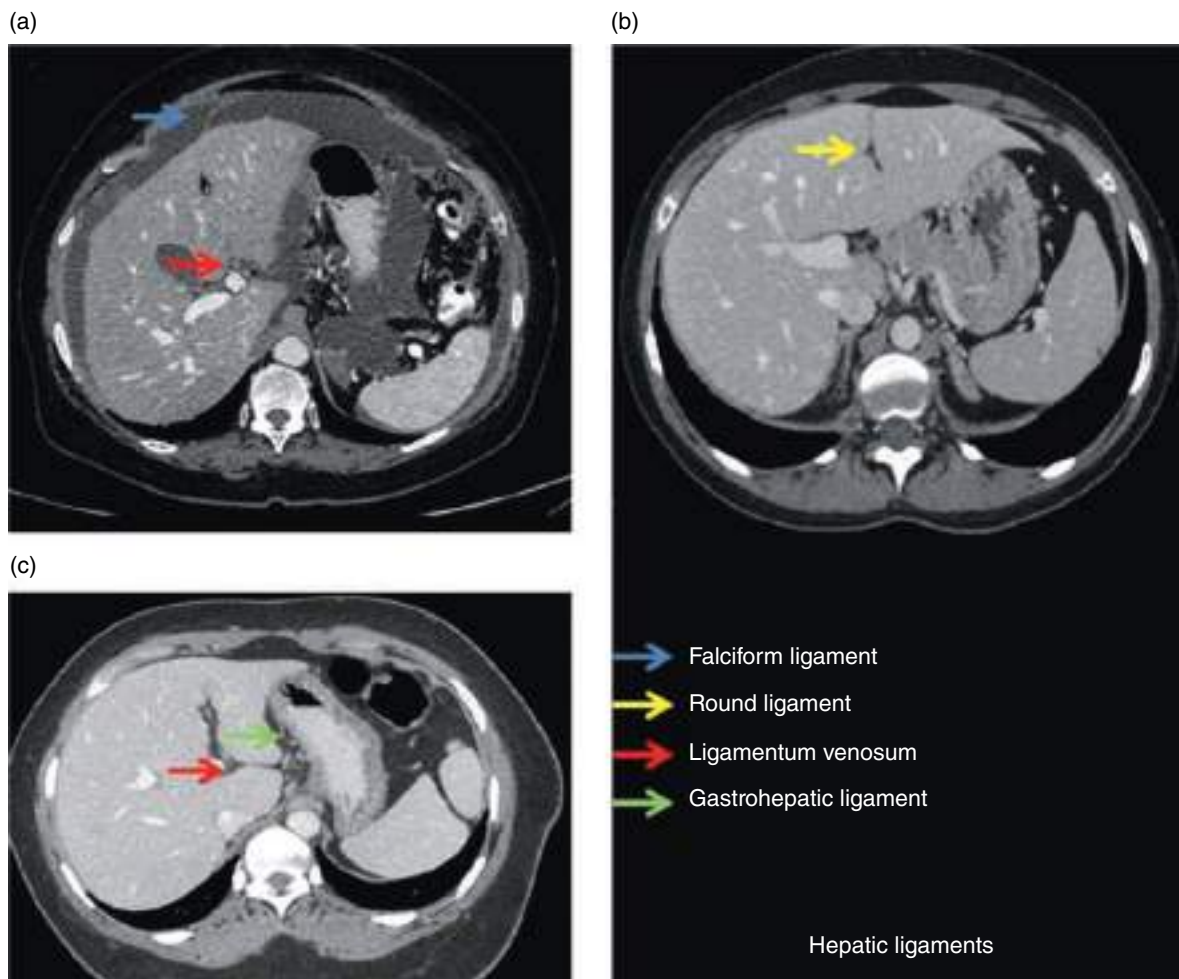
Ligaments of the liver. (a–c) Axial contrast-enhanced CT images (portal venous phase).
